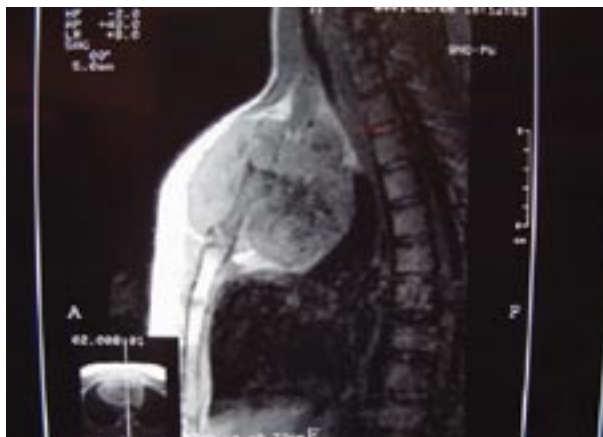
Chest CT scan, lateral view, demonstrating a solid osteoblastic tumor in the sternum.
